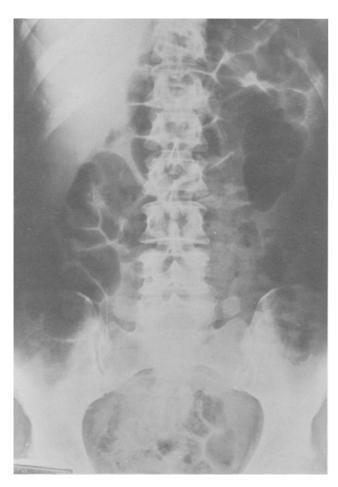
X-ray of the abdomen two months after sigmoid colectomy for subacute volvulus showing gross dilatation of the whole colon down to the anorectal ring.
